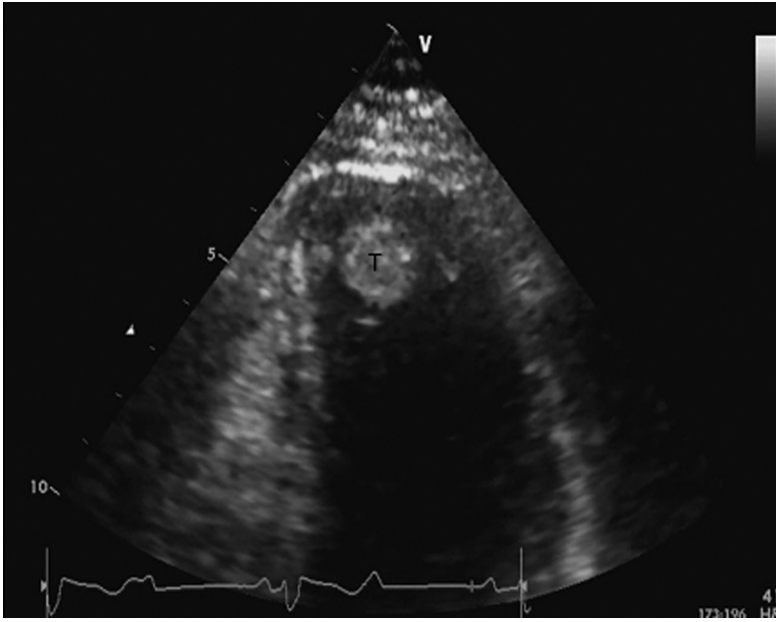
Echocardiogram demonstrating well-circumscribed mass at the left ventricular apex consistent with thrombus (T).
